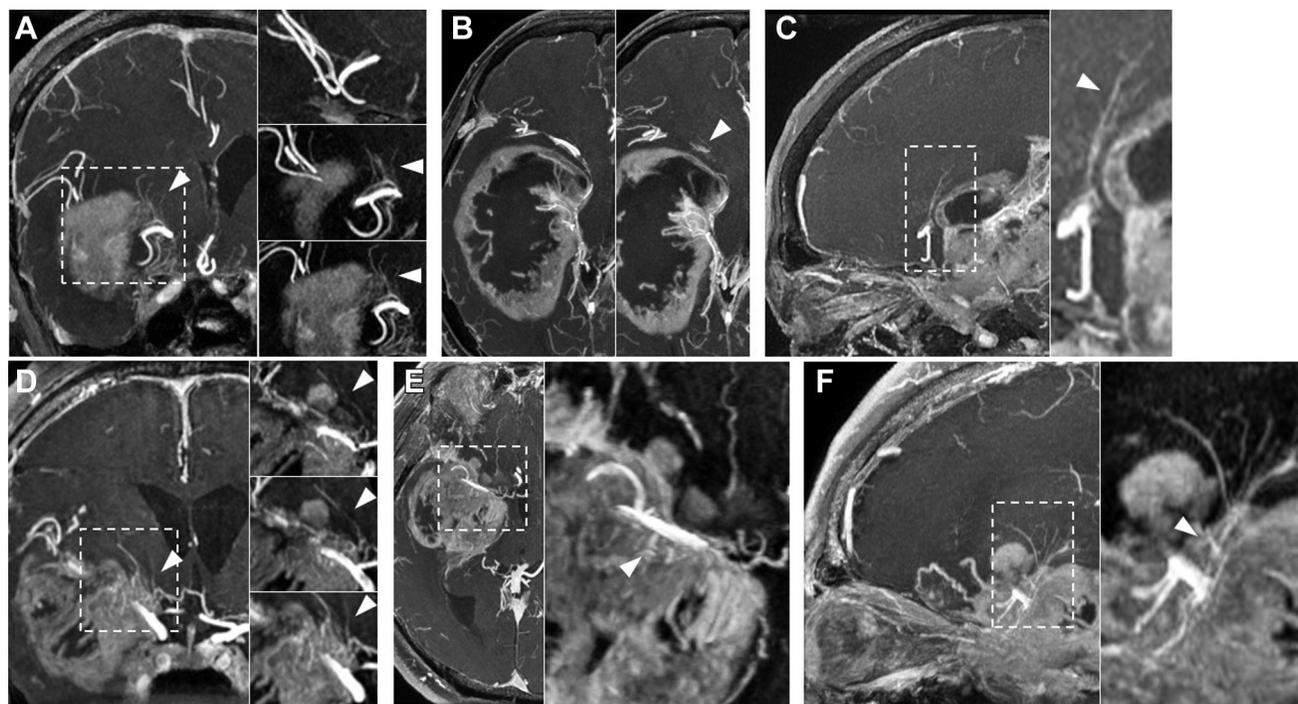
Representative 3-dimensional 3-Tesla time-of-flight magnetic resonance imaging of the lenticulostriate arteries (LSAs) in mimicking and invading types. *Triangles* indicate LSAs. Images with *dashed rectangle* have larger images on the right. Coronal images (A and D), axial images (B
